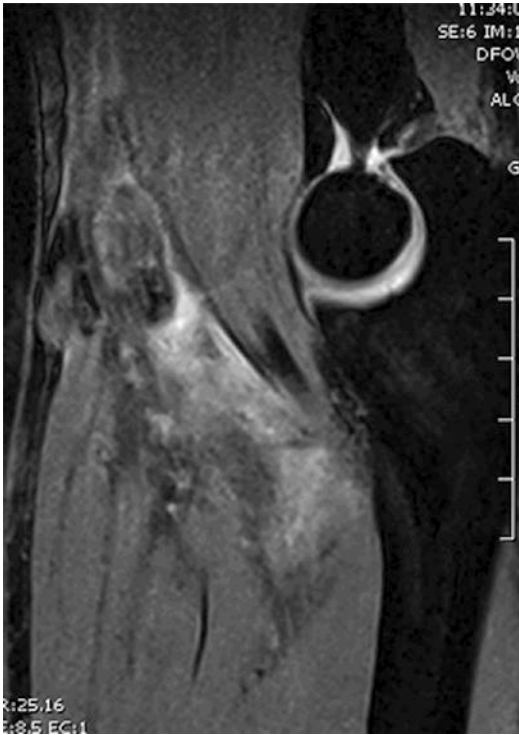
MRI demonstrating a ruptured distal biceps tendon
